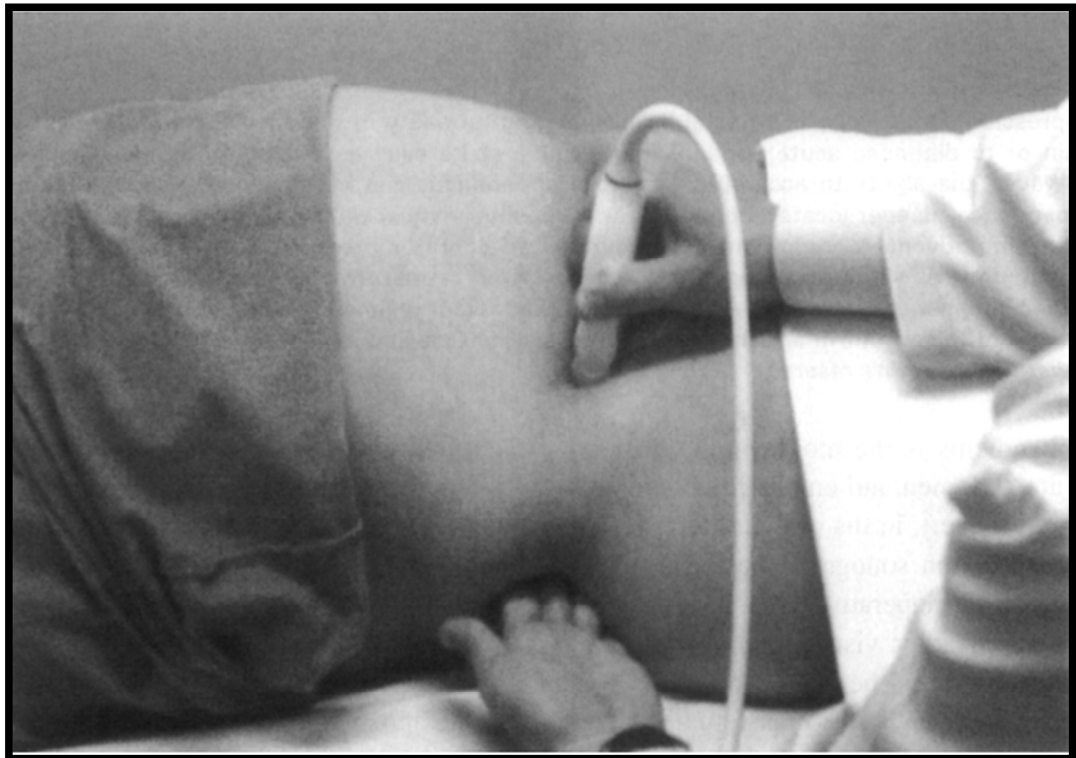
Ultrasonography of right iliac fossa to visualise appendix
